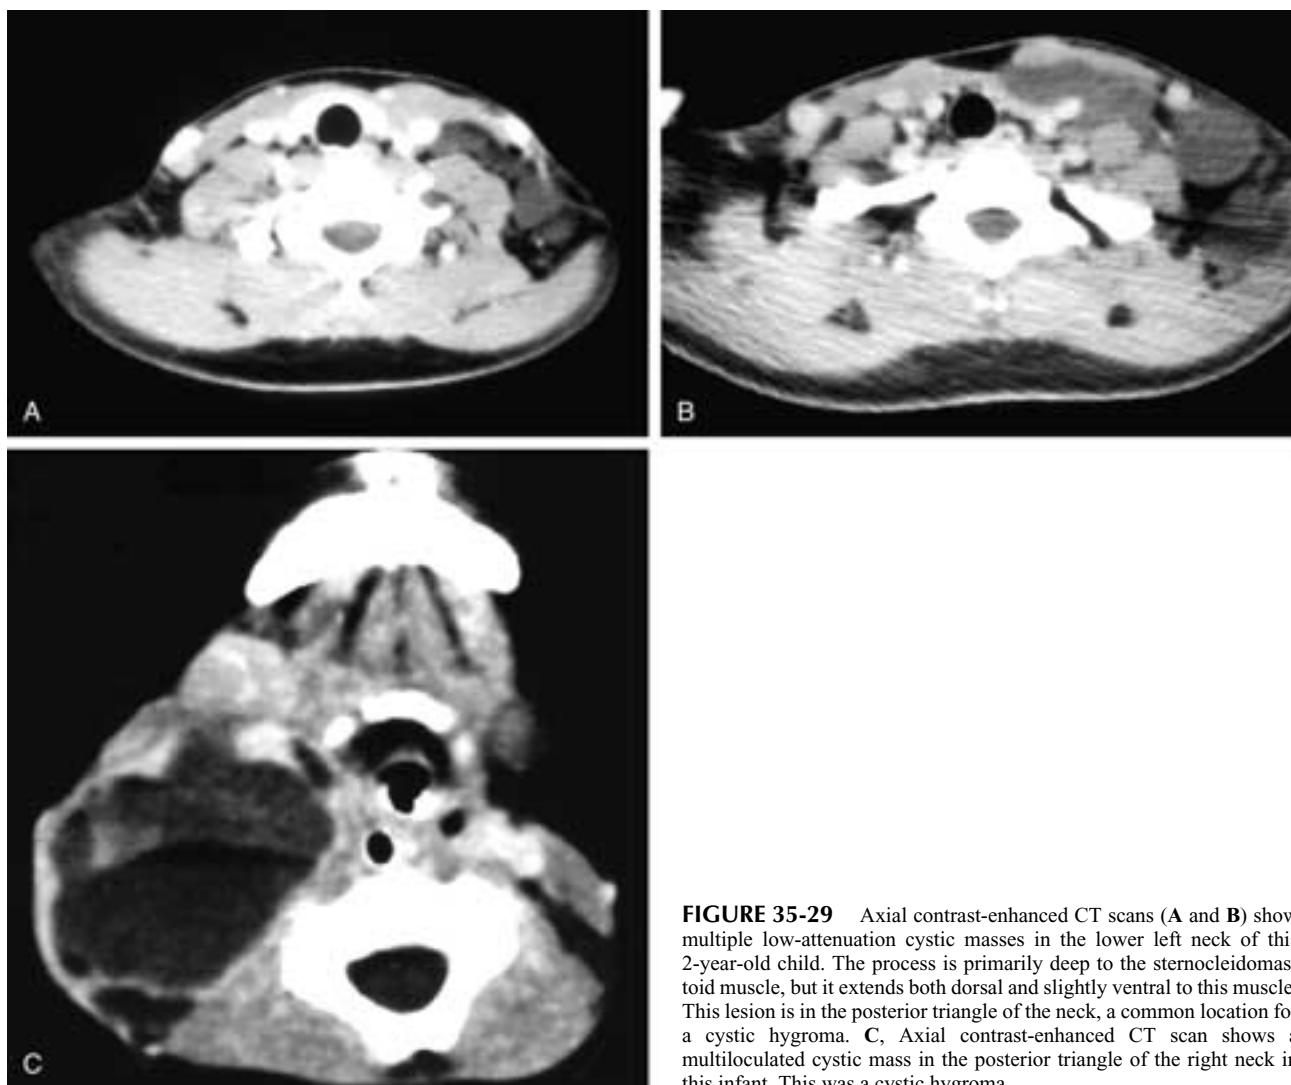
Axial contrast-enhanced CT scans (A and B) show multiple low-attenuation cystic masses in the lower left neck of this 2-year-old child. The process is primarily deep to the sternocleidomastoid muscle, but it extends both dorsal and slightly ventral to this muscle. This lesion is in the posterior triangle of the neck, a common location for a cystic hygroma. C, Axial contrast-enhanced CT scan shows a multiloculated cystic mass in the posterior triangle of the right neck in this infant. This was a cystic hygroma.
